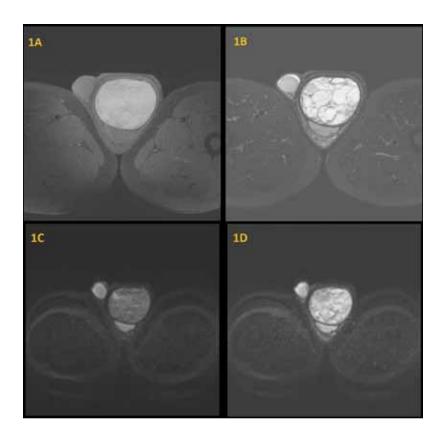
Magnetic resonance images: (A) T1 sequences; (B) T2 sequences; (C-D) diffusion weighted imaging sequences.
